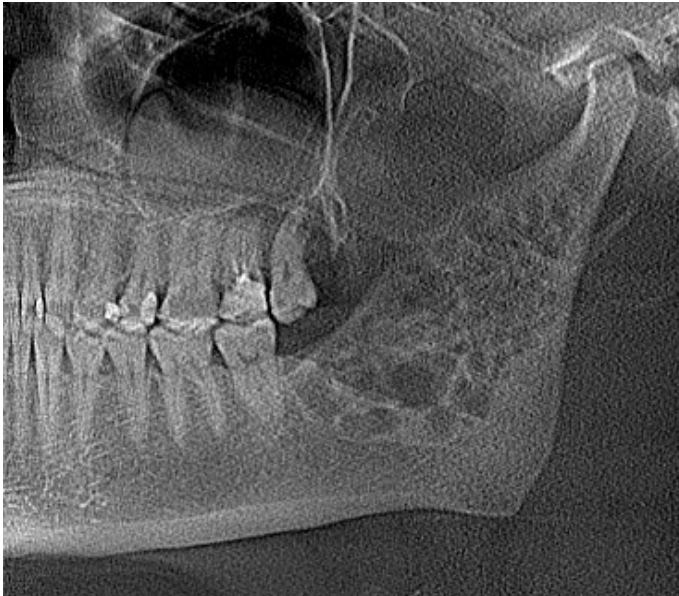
A panoramic radiograph (cropped), which was obtained on a routine examination, showed a multilocular radiolucency in the left ramus of the mandible, extending from the neck of the condyle to region d. 37 distally.
